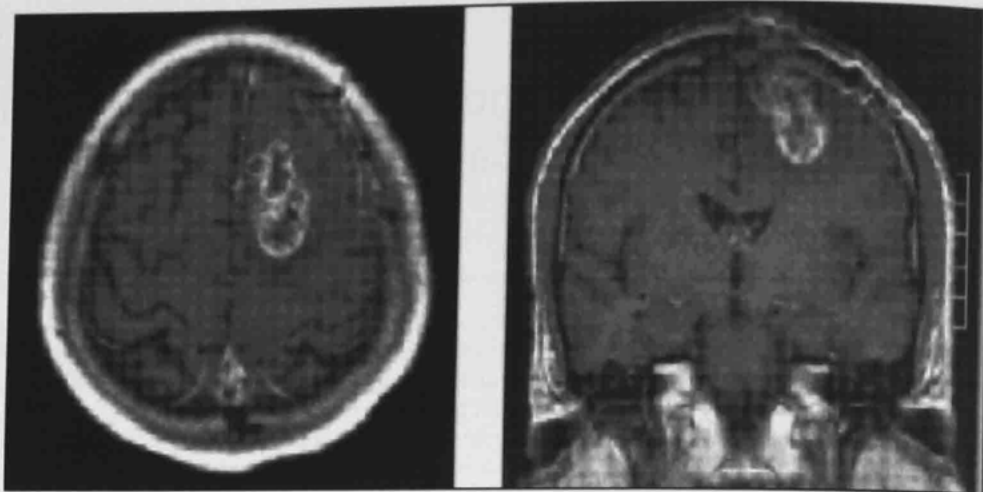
Axial and Coronal MRI images of a 43 year old male with a frontal metastasis.
